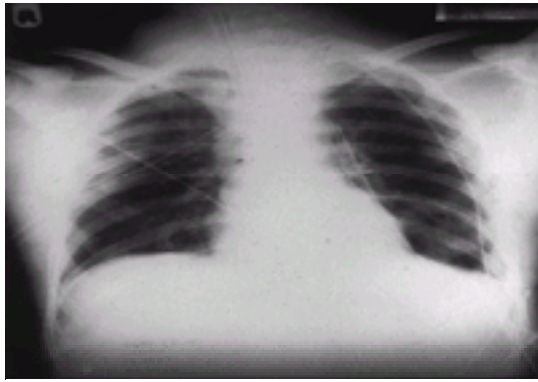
Plain chest radiograph after left thoracotomy to repair a ruptured diaphragm. The patient has surgically placed apical and basal drains on the left and a percutaneously situated drain on the right.
